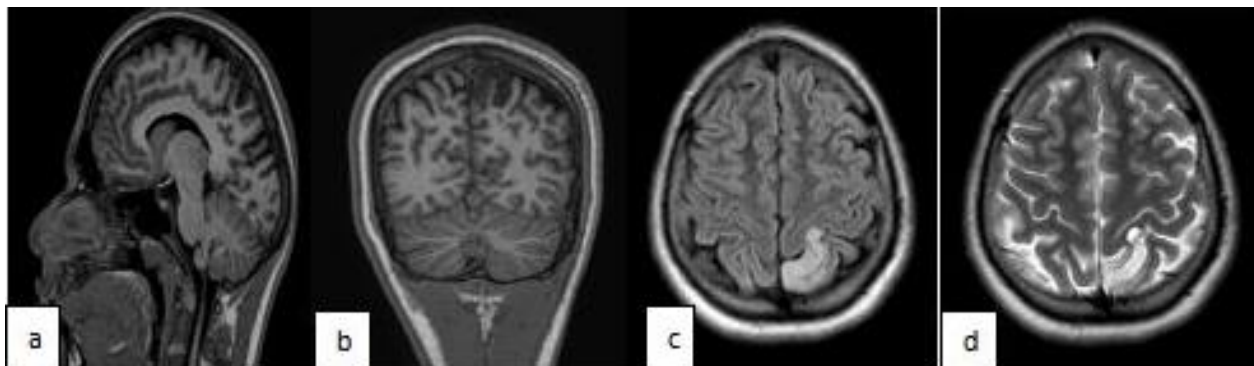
Preoperative images. (a & b) Saggital, Coronal T1-weighted MR image shows a cortical-based superficial lesion in left parietal lobe extending to the cortical margin. Axial FLAIR (c) T2-weighted axial image showing internal focal regions of high signal intensity, compatible with a “soap bubble” appearance (d) FLAIR axial view showing the lesion.
